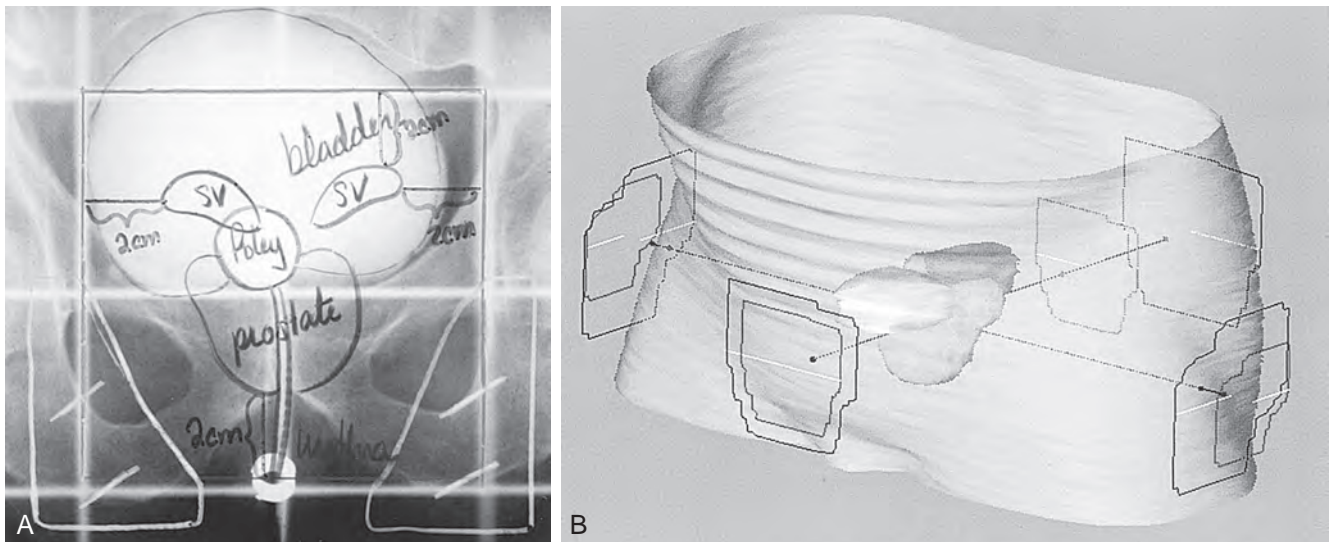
A, Conventional radiation therapy treatment portal, anterior view. The location of the prostate is inferred from the location of the Foley balloon and from contrast in the bladder, as well as from the location of the wire anal marker. B, Conformal radiation therapy portal, anterior view. The fully three-dimensional prostate volume is reconstructed from the planning computed tomography scan. SV, seminal vesicles.
